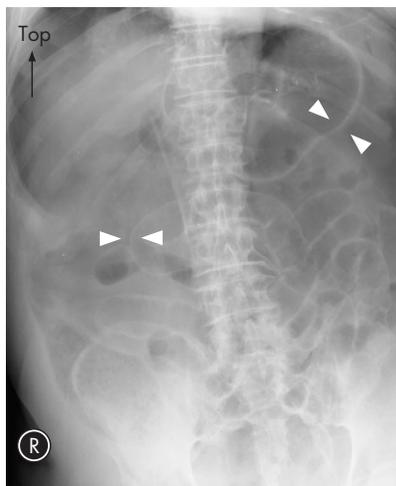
Massive pneumoperitoneum and Rigler’s sign (double-wall sign) on abdominal radiography: the bowel wall is outlined by air both inside and outside (white arrows).
